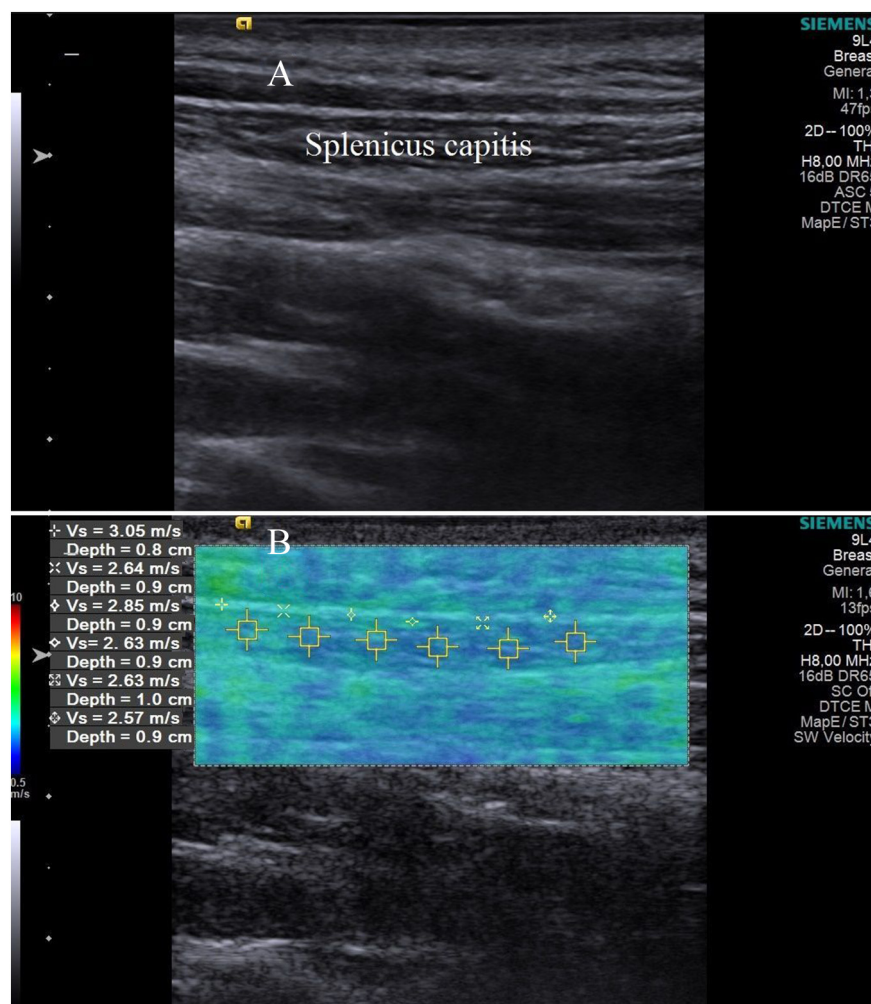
Two-dimensional ultrasound image of the splenius capitis muscle (A). Color map shear wave elastography image of the splenius capitis muscle in the longitudinal plane (B). Ranges of image were placed in the muscle, and corresponding shear wave velocity (m/sec) values were recorded. The shear wave velocity of the tissues increases in the order of blue-green-red color-coded areas.
